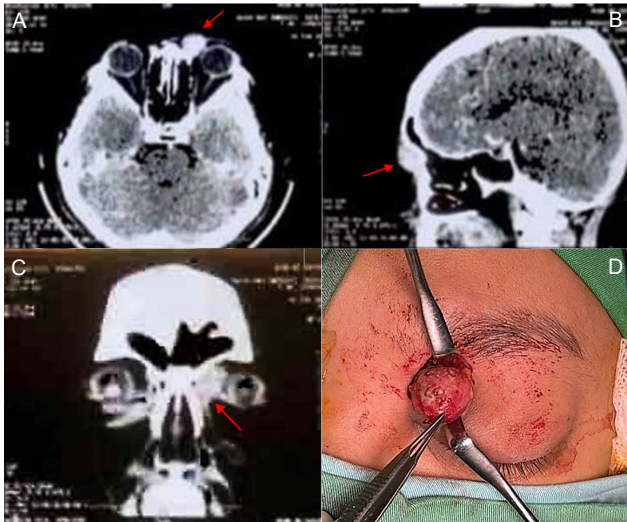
(A-C) Contrast CT-Scan of the head revealed a solid mass, size +/- 1.7 x 1.7 x 2.1 cm on the left medial pre-septal side suggesting a benign tumour suspect dermoid cyst (red arrow); (D) Complete removal of the mass.
